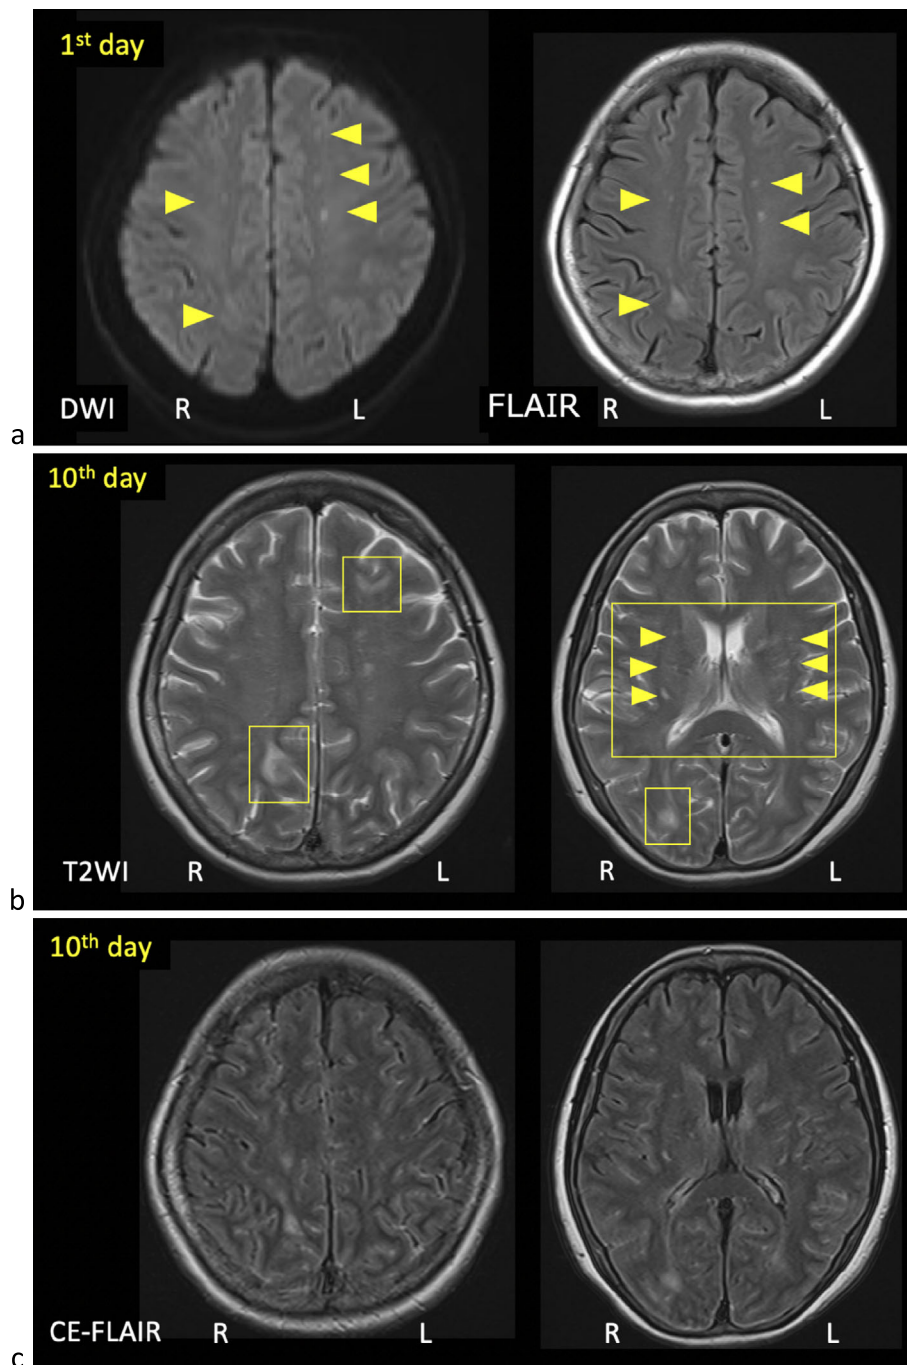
Initial MRI findings. a) Diffuse high-signal areas in the bilateral cerebral hemispheres on diffusion-weighted and FLAIR images. b) Subcortical high signal and linear high signal around the lateral ventricles on post-contrast T2-weighted images. c) Contrast effects with subarachnoid pattern on post-contrast FLAIR images. Arrowheads indicate high-intensity lesions. CE-FLAIR: contrast-enhanced fluid-attenuated inversion recovery, DWI: diffusion-weighted imaging, L: left, R: right
